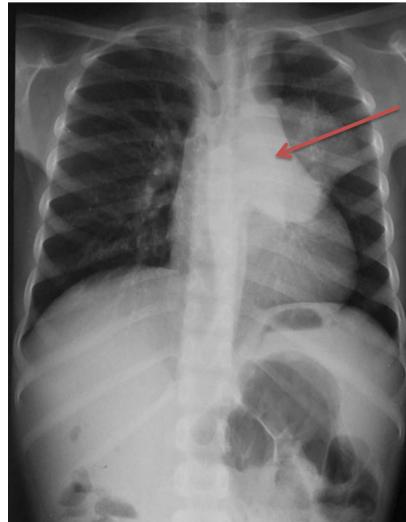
Front chest X-ray: dense para hilar mass in the left mediastinum.
